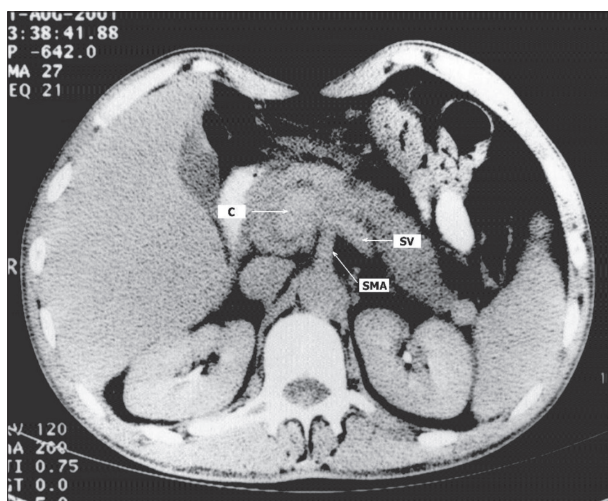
Computed tomography showing contrast within the central area of the cyst – C;
